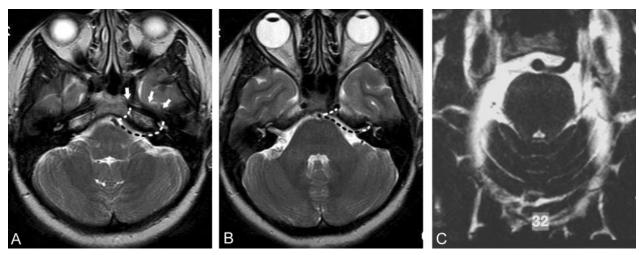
Axial T2-weighted MR imaging at level of petrous canal (*A, white arrows*) and at level of IAM (*B*). In both, dotted lines show posterolaterally the predicted course of an otic artery through the IAM to join the lateral portion of the petrous ICA. In *A*, the anteromedial dotted line shows the course of a low-lying trigeminal artery and, in *B*, the typical course of a trigeminal artery. *C*, Actual recent case of a trigeminal artery joining the cavernous ICA. The anomalous vessel is readily visible on standard cross-sectional images, and a true otic artery of the size shown by Patel et al would be equally visible on any standard MR imaging sequence.
